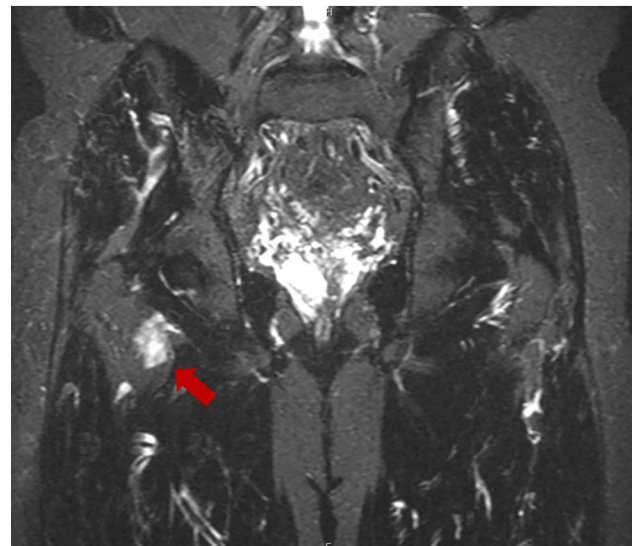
T2-weighted magnetic resonance imaging showing high signal intensity at the lesser trochanter.
